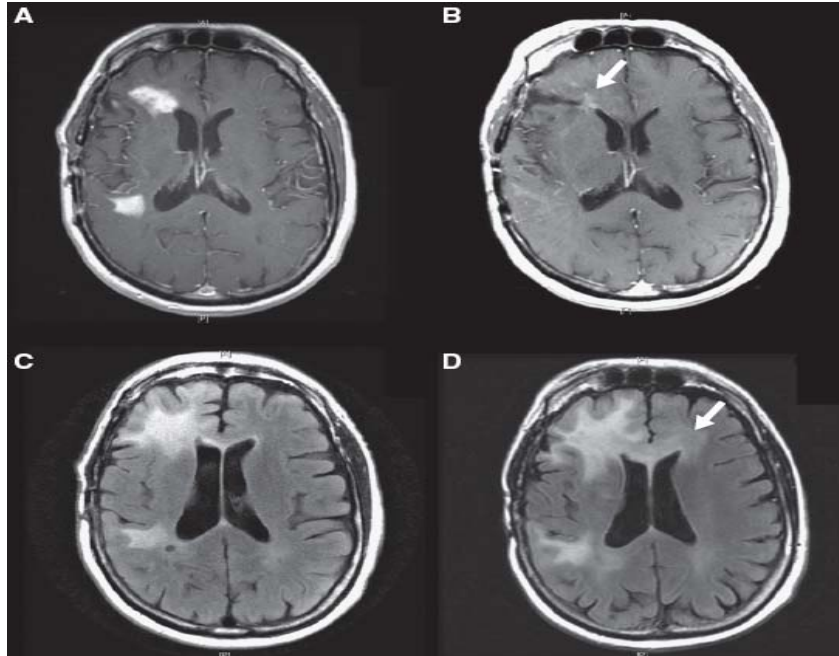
A patient of 54 years with progressive, recurrent glioblastoma, refractory to treatment with TMZ and bevacizumab. A) T1-enhanced MRI showing a multifocal glioblastoma right frontal lobe. B) Regression of tumor mass 7 months after therapy, according to MacDonald criteria. C) MRI / FLAIR. D) MRI after another seven months showing corpus callosum invasion and progression of tumor mass in the left frontal lobe.
